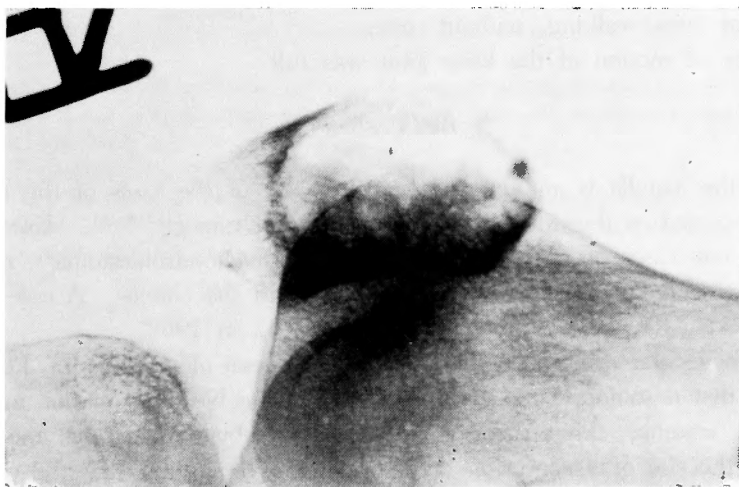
Roentgenogram of the right knee joint shows the cystic radiolucent area which occupies proximal two thirds of the patella.
